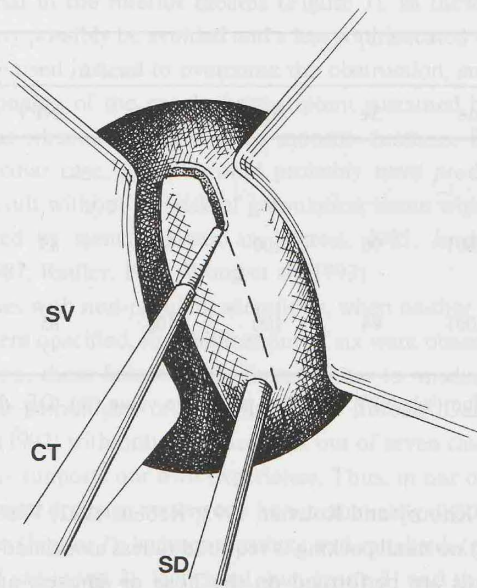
Left nasal fossa. A posterior pedicled flap of nasal mucosa is made and turned backwards (SV: nasal speculum valves; CT: coagulating tip; SD: suction device).
